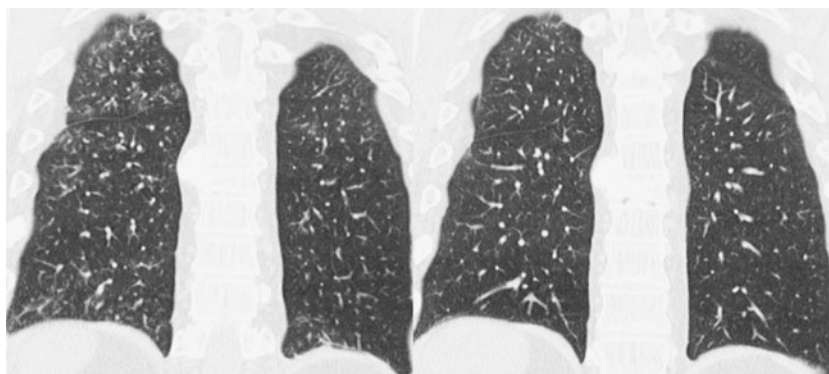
Longitudinal CT findings in a 15-years old heart-lung transplant recipient with BOS responding to azythromycin (neutrophilic reversible allograft dysfunction (NRAD)). Four axial thin-slice CT images at inspiration before (*left*) and after (*right*) treatment with azithromycin in a patient who responded favorably. The pre-treatment CT images on the left demonstrate bronchial dilatation, bronchial wall
